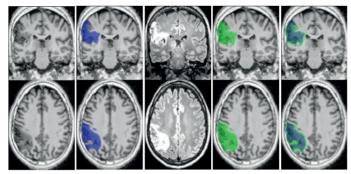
An example of how lesion estimation can differ between MRI sequences.
